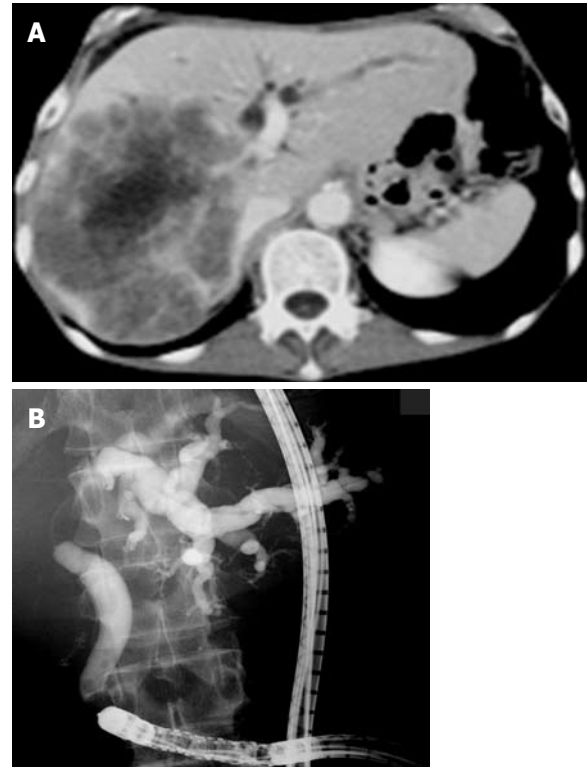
The hilar biliary obstruction due to liver metastasis occupying the right lobe and a dilated left intrahepatic bile duct with tumor invasion extending to the bifurcation of the lateral bile duct branch. A: Computed tomography image; B: Cholangiography.
